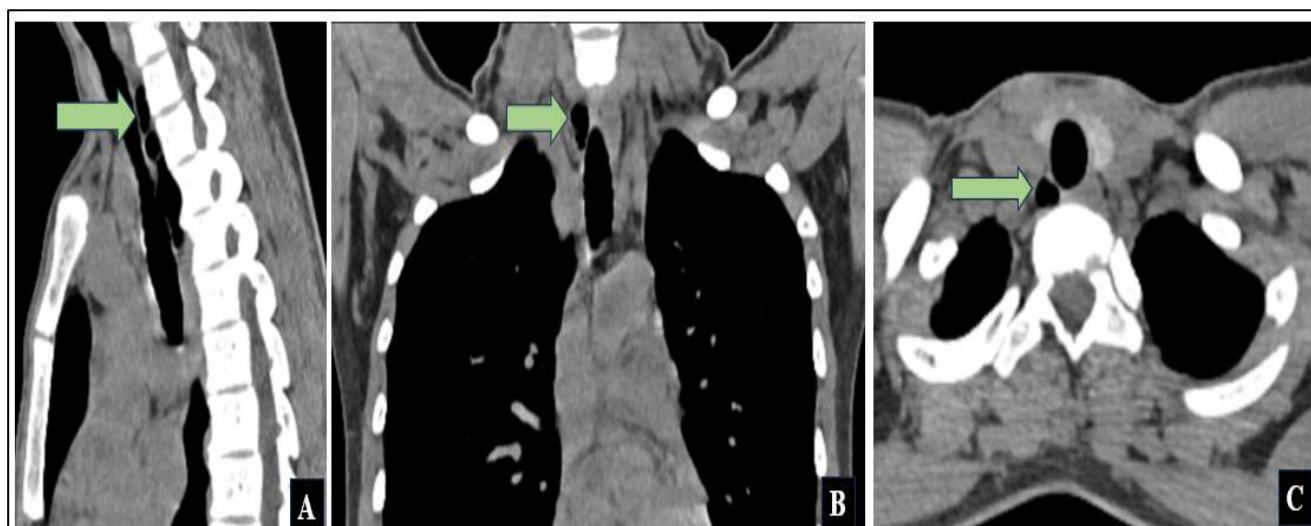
Sagittal (A), coronal (B) and axial (C) section of CT scan chest images showing multiloculated tracheal DV (green arrows) in right posterolateral aspect of trachea.
